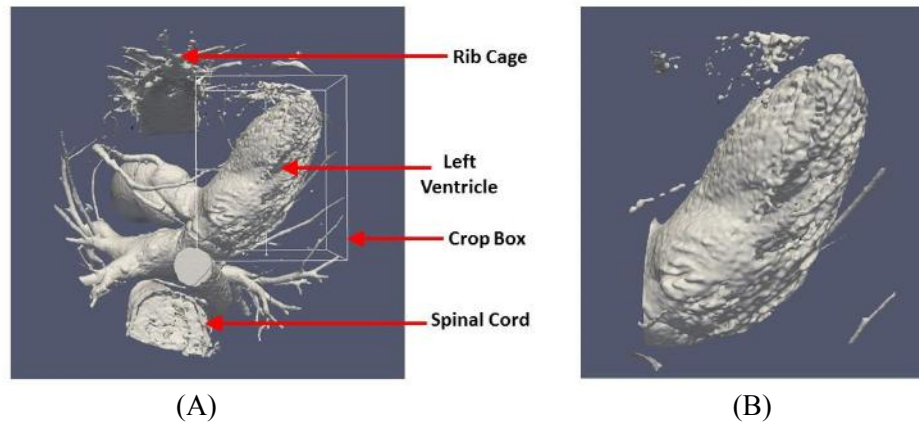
Cropping of the left ventricle. (A) 3-D reconstruction of a Cardiac CT scan. (B) The left ventricle cropped out.
